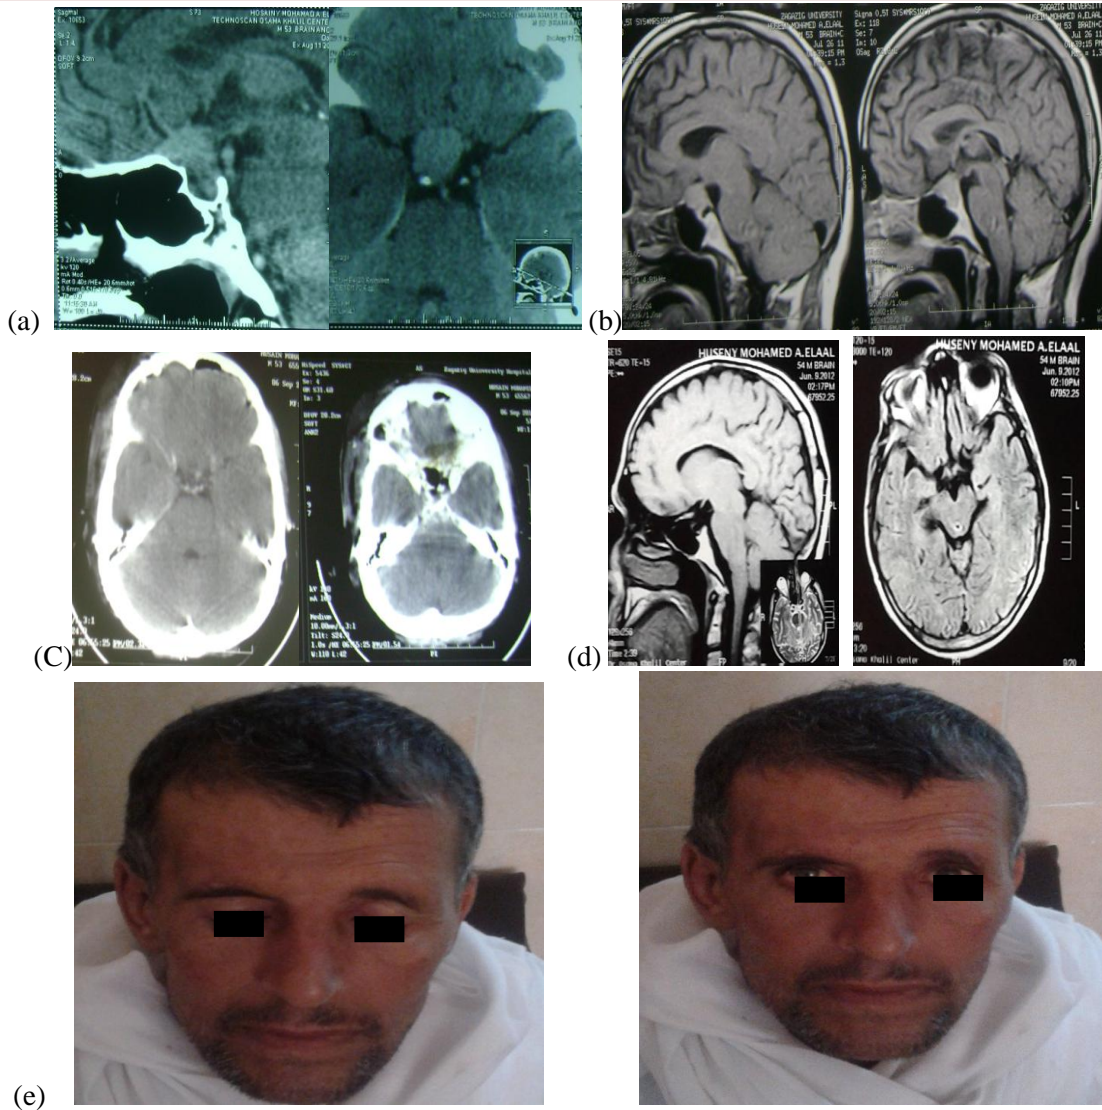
[A] Preop CT, [B] MRI shows planum sphenoidal menengioma.[C] Postop CT scan shows total removal ,[D] MRI, 9 months postop. [e] patient , 6 months postop (no visible scar or disfigurement)..
